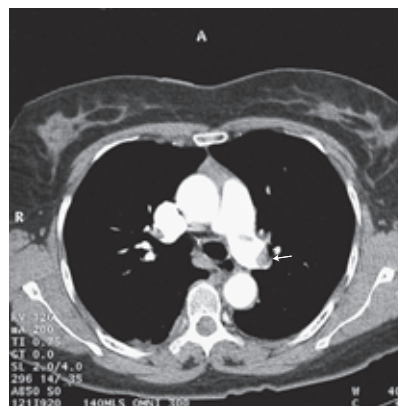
CT scan demonstrating filling defect in proximal left pulmonary artery (arrow) from thrombus. Distal branches of artery are occluded. (From Souhami R: *Textbook of Medicine*, New York, Churchill Livingstone, 2002, figure 13.6.2A.)
